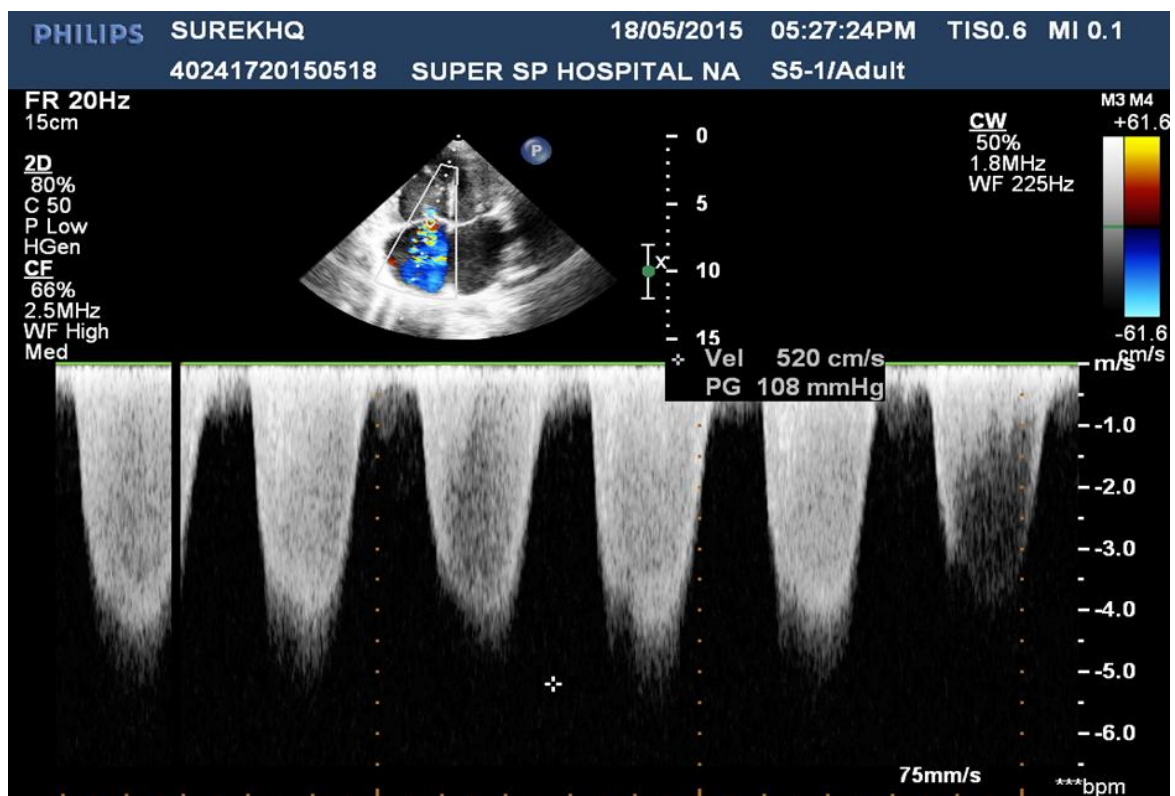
2DECHO in apical 4 chamber view showing severe pulmonary hypertension. (PASP by TR Jet 108 mmHg)
